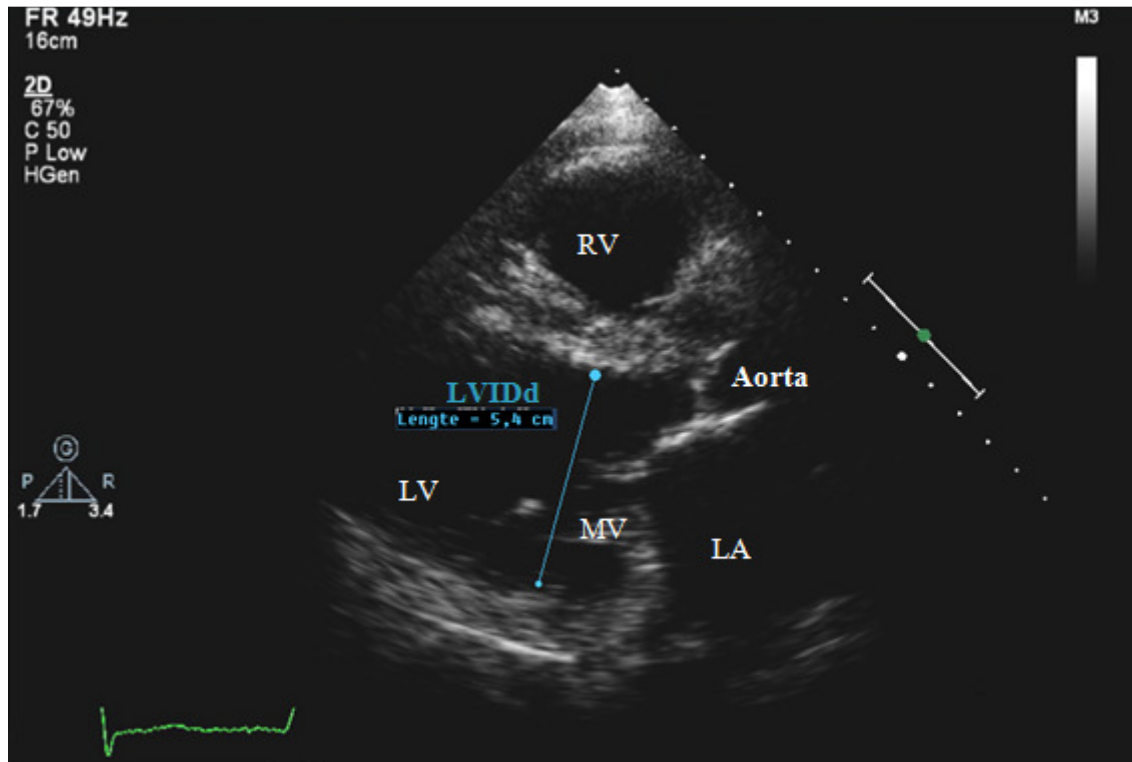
ECHOCARDIOGRAPH LAX IMAGE, along with the measurement of the left ventricular diameter in diastole (blue line), measured against the tip of the mitral valve in the left ventricle. MV: Mitral Valve ; LV: Left Ventricle ; RV: Right Ventricle ; LA: Left Atrium
